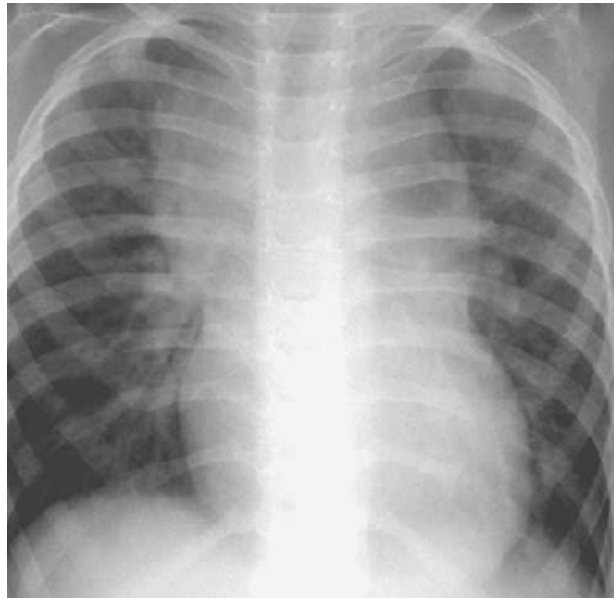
Roentgenography (X-ray radiography)
